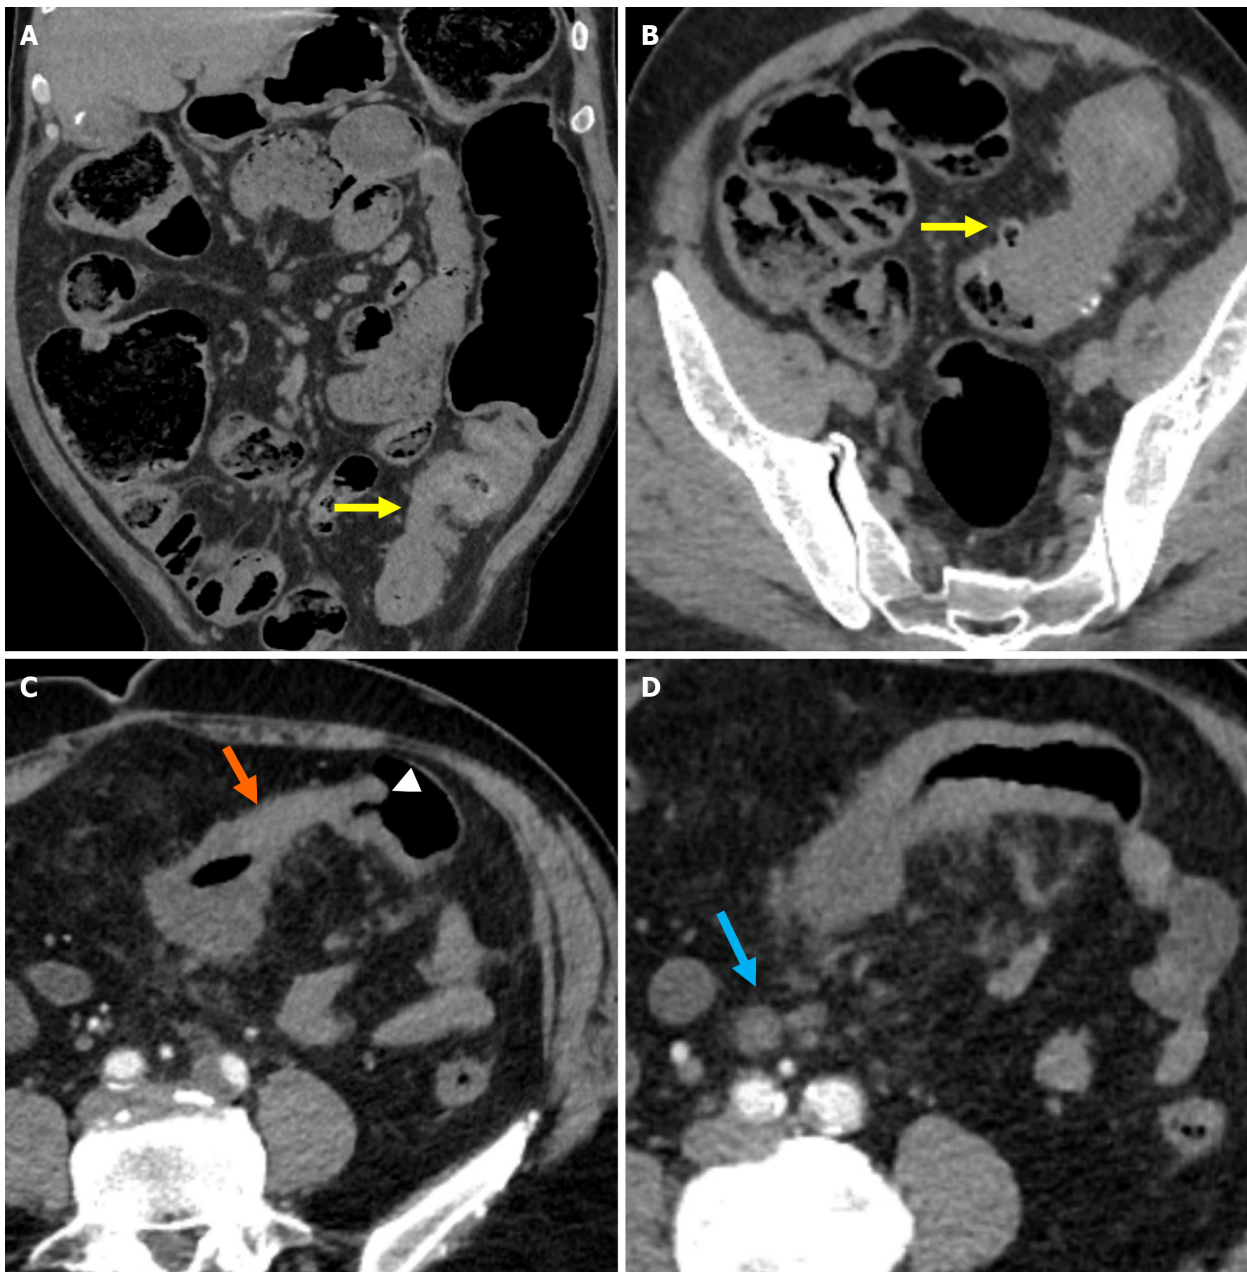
Distinguishing features of chronic sigmoid diverticulitis and colorectal cancer. A and B: Non-contrast-enhanced coronal reformatted computed tomography (CT) image and non-contrast-enhanced axial CT image showed long-segment, diffuse wall thickening in the sigmoid colon, luminal narrowing due to fibrosis, and diverticula (yellow arrows). Recurrent obstruction with proximal bowel loop dilatation was evident. The absence of pathological lymphadenopathy in the mesocolon served as a key diagnostic clue; C: Marked wall thickening of the affected bowel segment (orange arrow) with the shoulder phenomenon (white arrowhead) without visible diverticula; D: Rounded, metastatic lymph nodes (blue arrow) in the mesentery of the affected sigmoid segment accompanied by fat stranding consistent with pericolic fat infiltration.
